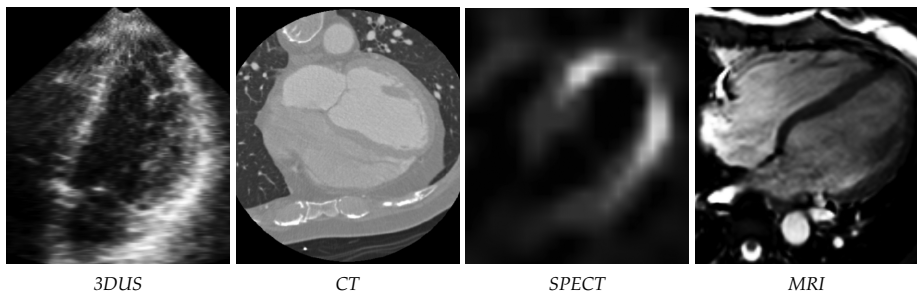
Images from different modalities: 3DUS= Three-dimensional ultrasound; CT= Computed Tomography; MRI= Magnetic Resonance Imaging; SPECT= Single Photon Emission Computed Tomography.
